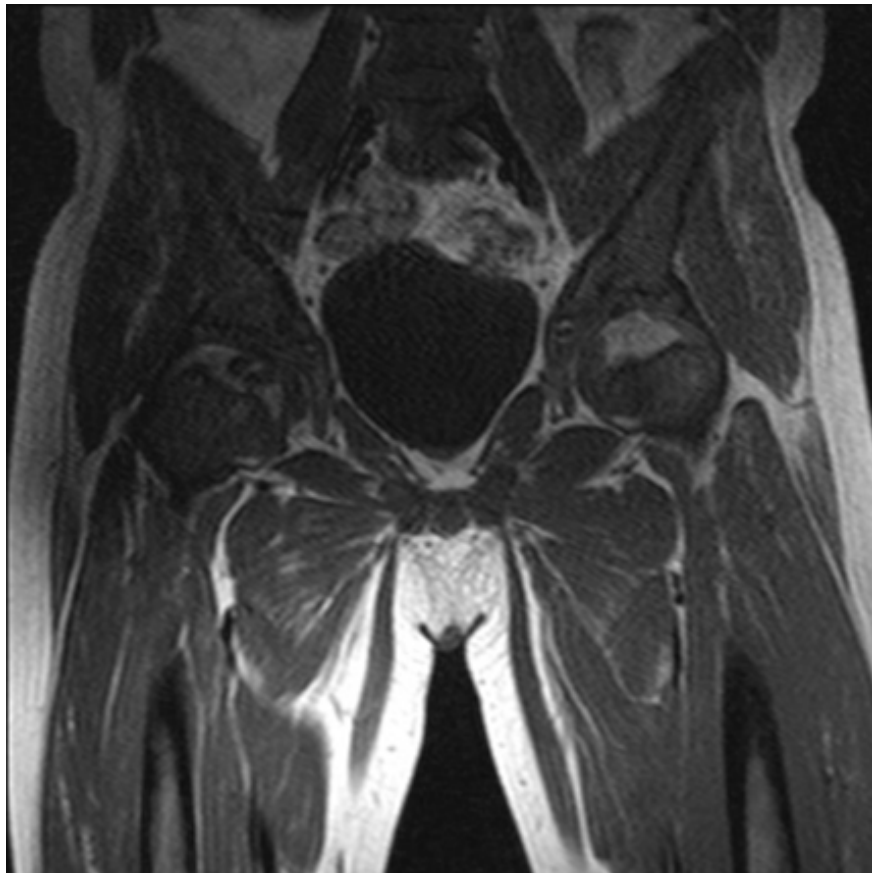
MRI and c: post op
